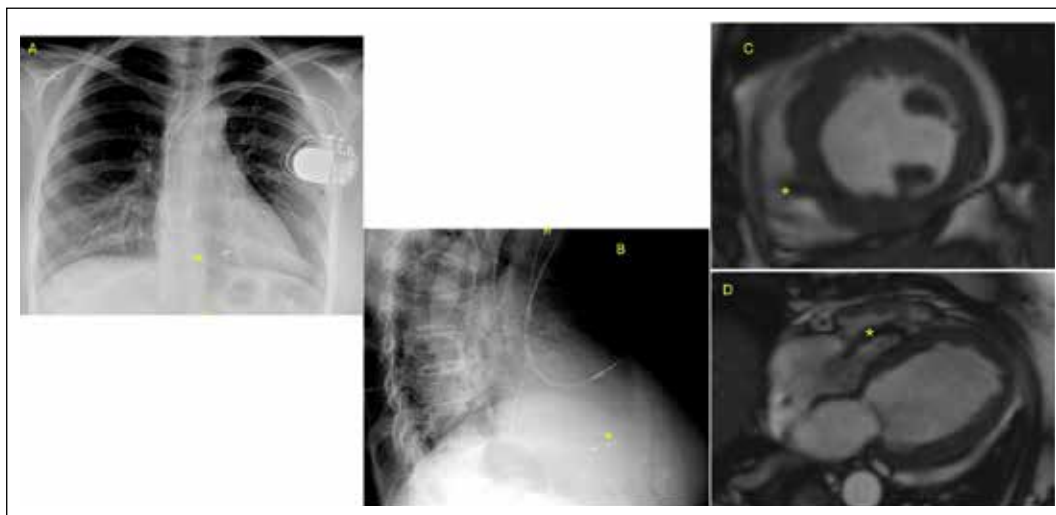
Images showed lead positions in a case of dual chamber left bundle pacing in frontal and lateral radiographs (A, B). Note that the ventricular lead appears thinner than the atrial lead, which suggests a Medtronic 3830 lead (denoted by an asterisk*). CMR of the same person after pacing shows the position of the 3830 lead (denoted by asterisk*) in the basal interventricular septum (C, D).
